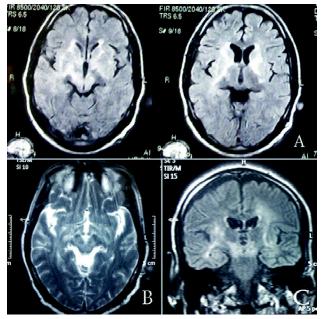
Axial FLAIR MRI at first presentation showing hyperintensities in the midbrain, bilateral superior cerebellar peduncles, mesial temporal lobes and basal ganglia.
